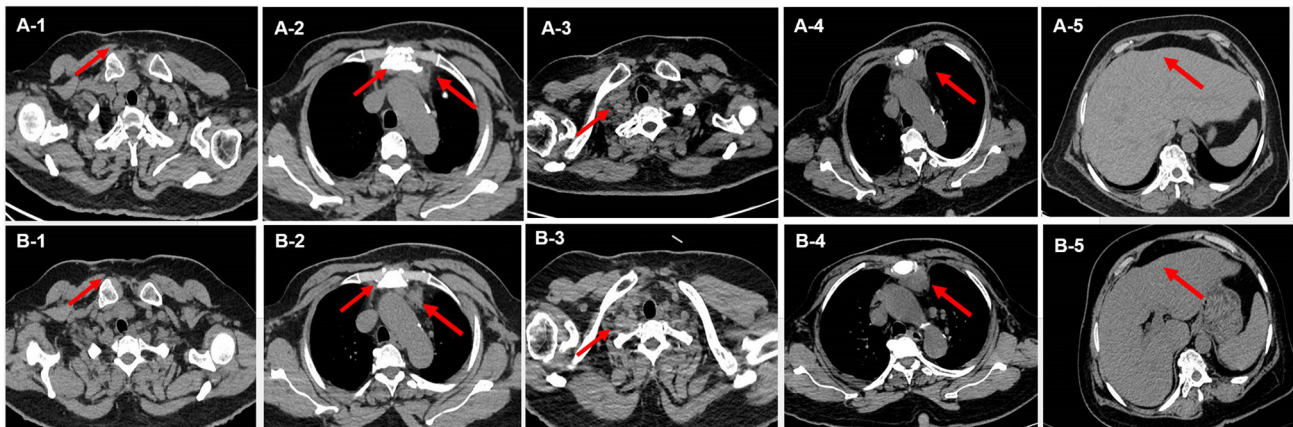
Chest and abdominal CT scans showing steady augmentation (SDb) with vinorelbine combined with capecitabine. (A-1 and B-1) Chest wall metastasis. (A-2 and B-2) Sternal bone destruction with soft-tissue mass formation. (A-3 and B-3) Left supraclavicular lymph node metastasis. (A-4 and B-4) Mediastinal lymph node metastasis. (A-5 and B-5) Liver metastasis. (A-1, A-2, A-3, A-4 and A-5) Baseline images (January 2024) and (B-1, B-2, B-3, B-4 and B-5) images after treatment (April 2024) are shown. Metastatic lesion size enlargement: (A-1) 0 cm to (B-1) 0 cm, (A-2) 2.1x2.0 cm to (B-2) 2.1x2.2 cm, (A-3) 2.0x1.9 cm to (B-3) 2.0x2.2 cm, (A-4) 2.4x2.0 cm to (B-4) 2.5x2.1 cm, (A-5) 0 cm to (B-5) 0 cm. CT, computed tomography.
